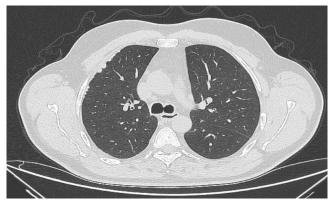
High-resolution CT scan of the right lung parenchyma showing nodular pleural plaques in Case 6
